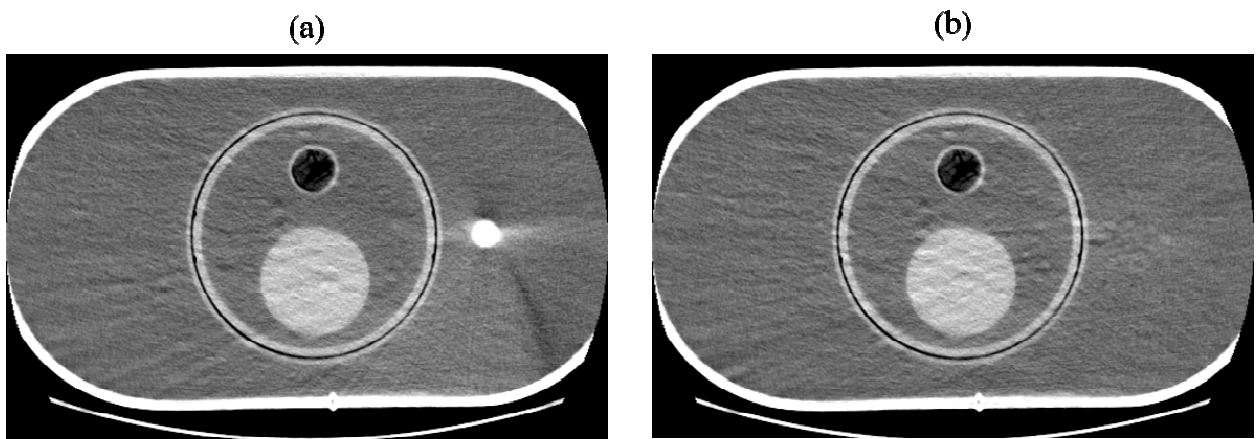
CT image of the most superior aspect of the femoral head portion of a hip prosthesis for (a) GSI imaging without MARs and (b) GSI imaging with MARs applied.
